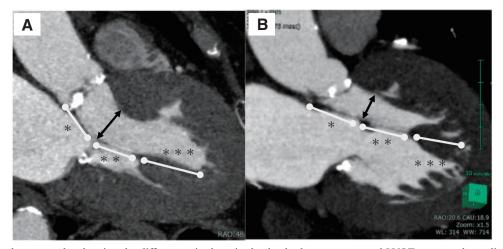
Computed tomography showing the differences in the mitral subvalvular apparatus and LVOT statuses depending on the cardiac phase. In the systolic phase (A), the passage through the aortic valve is wide, but in the diastolic phase (B), the passage through the aortic valve is narrow. (*mitral valve leaflet, chordae tendineae, and *papillary muscle.) LVOT: left ventricular outflow tract
